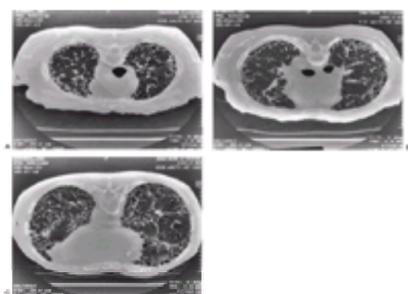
High-resolution chest CT (1.5-mm slices) of a patient with IPF. Apical (A), midlung (B), and basilar (C) cuts are shown. These sections demonstrate marked peripheral fibrotic changes with cystic honeycombing most prominent at the bases of the lungs.
